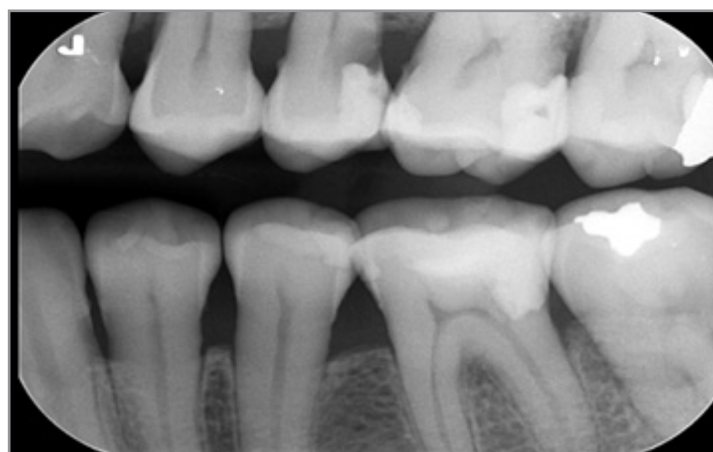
Bite-wing X-ray after CLP and endodontic procedure
